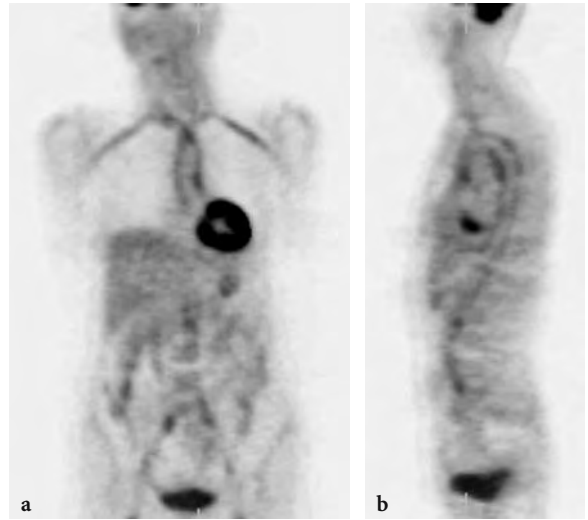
A 64-year-old woman with unexplained weight loss and elevated erythrocyte sedimentation rate. FDG PET showed increased vascular FDG uptake in the thoracic and abdominal aorta, both subclavian, carotid, iliac, and femoral arteries suggesting vasculitis. She was eventually diagnosed with vasculitis and responded well to corticosteroids
